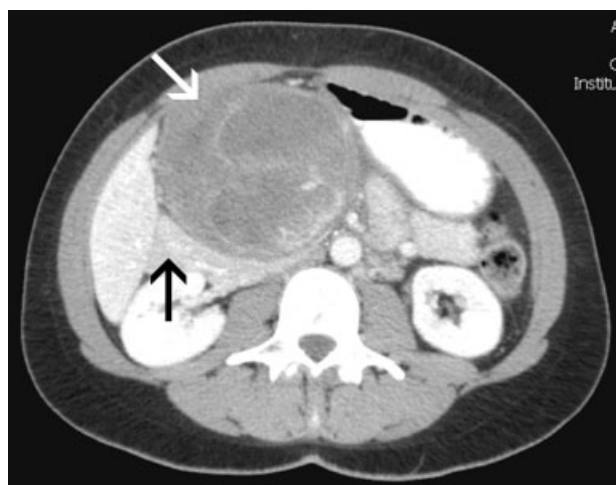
Computed tomography scan of a 46-year-old patient presenting with a 10 × 12-cm gastrointestinal stromal tumour of the stomach (white arrow). At operation, the tumour was found to displace, without infiltrating, the head of the pancreas (black arrow). A distal gastrectomy was performed
